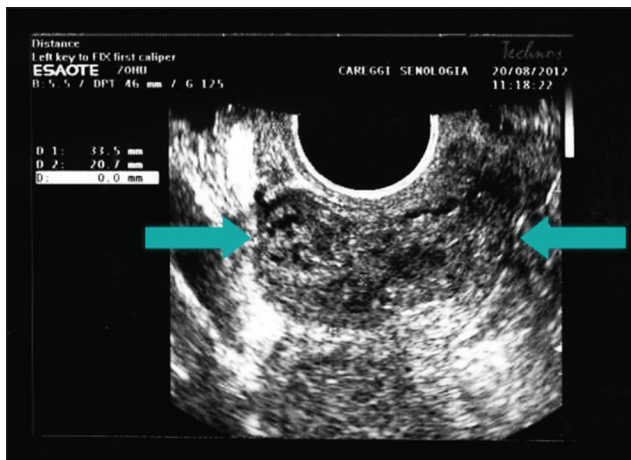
Ultrasound two-dimensional image of the cervix; the arrows outline the presence of the extra-uterine "mass"
